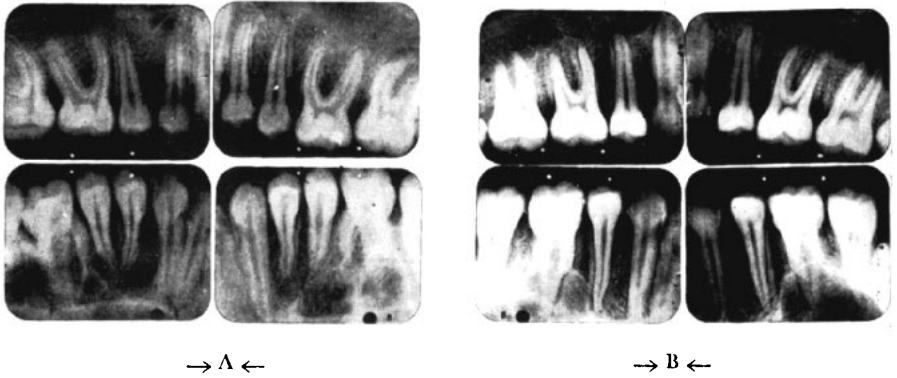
Intra-oral roentgenograms of two cases which were treated orthodontically. All the teeth were moved mesially. Note the prominent lamina dura on the distal surface of the bony alveoli. (Courtesy of Dr. C. H. Tweed.)
